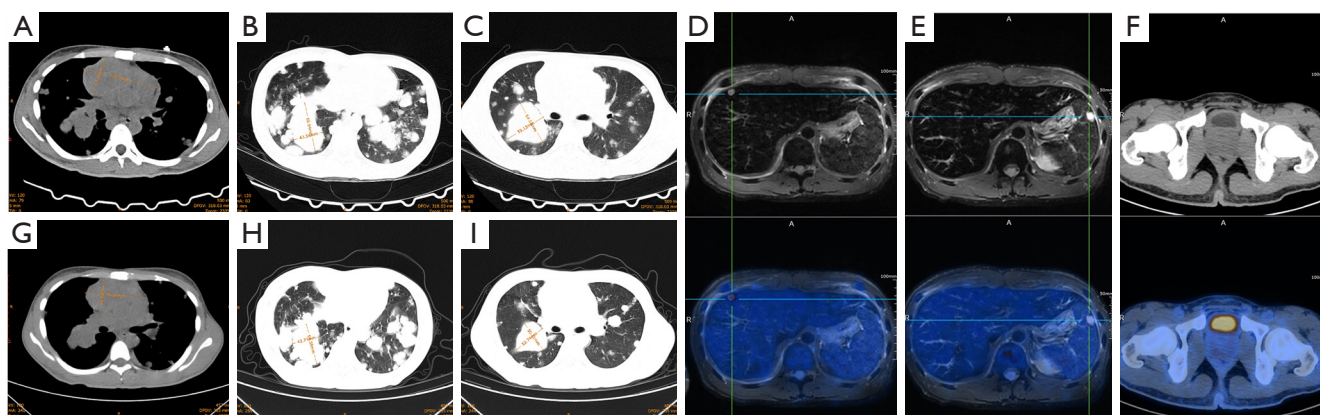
CT, PET/MRI and PET/CT scans evaluate the progression of disease. (A-C) CT scan of the thorax reveals an enlarged anterior mediastinal mass and multiple metastatic lung nodules after the one cycle of chemotherapy. (D,E) PET/MRI imaging demonstrates metastatic lesions in the liver and spleen. (F) PET/CT imaging showed no abnormal FDG accumulation in bladder and gonads. (G-I) Both mediastinal and pulmonary lesions are partially reduced after two cycles of pembrolizumab. CT, computed tomography; PET, positron emission tomography; FDG, ^{18}F -fluorodeoxyglucose; MRI, magnetic resonance imaging; A, anterior; R, right; L, left; DFOV, display field of view.
